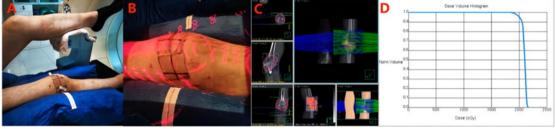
Position fixation and plan of radiotherapy (A, B) The patient lied down in the supine position, and was fixed with andvacuum bag marked in the surface. (C) The patient was treated with conformal radiotherapy with two radiation fields, linear accelerator 6 MV X-ray external irradiation. (D) Dose Volume Histogram (the total dose of 20 Gy).
